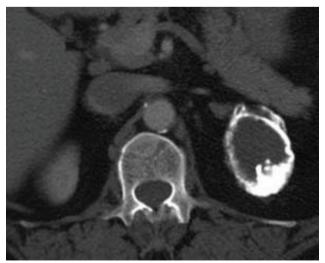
Left adrenal mass in abdominopelvic CT scan shows calcification.
